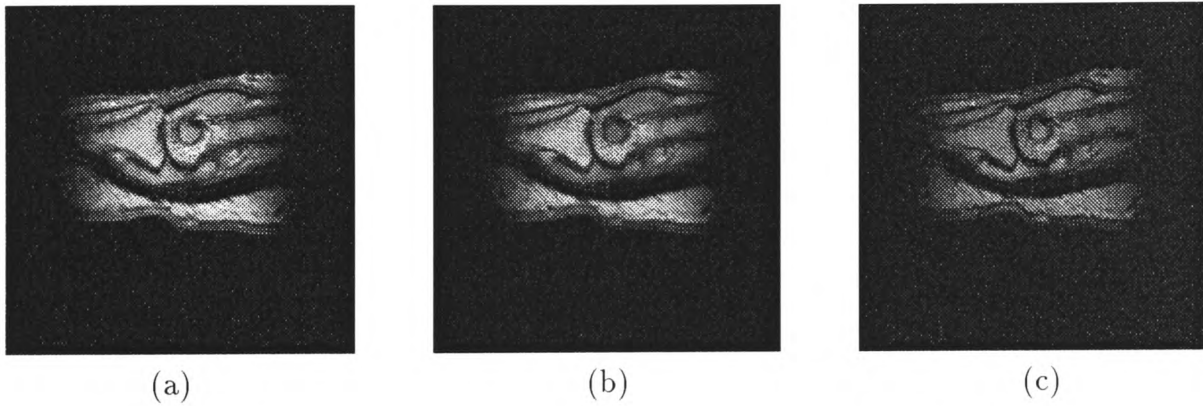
(a) PD-weighted image (b) T2-weighted image (c) T1-weighted image.
